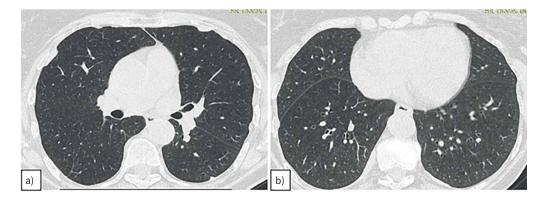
a, b) Axial images in a lung window of high-resolution computed tomography (0.625 mm slice thickness) of patient 2. No major parenchymal abnormalities were detected, apart from local pleural thickening (a stable finding over the past 5 years).
